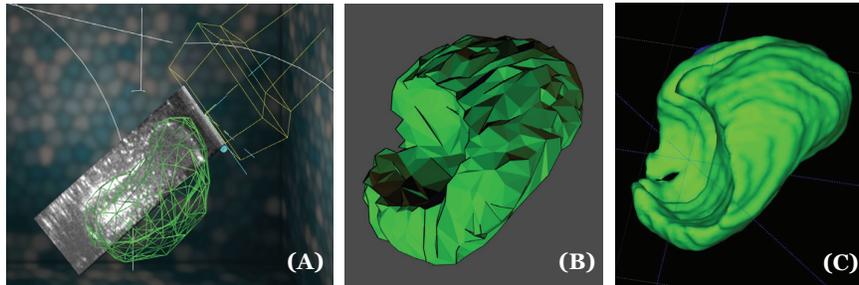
(A) Accurate registration between pre-segmented tumor (green wireframe) and real-time ultrasound scan. The partially ablated tumor calculated by the guidance system (B) approximately matches the remnant tumor (C) segmented from the post-ablation MRI.
